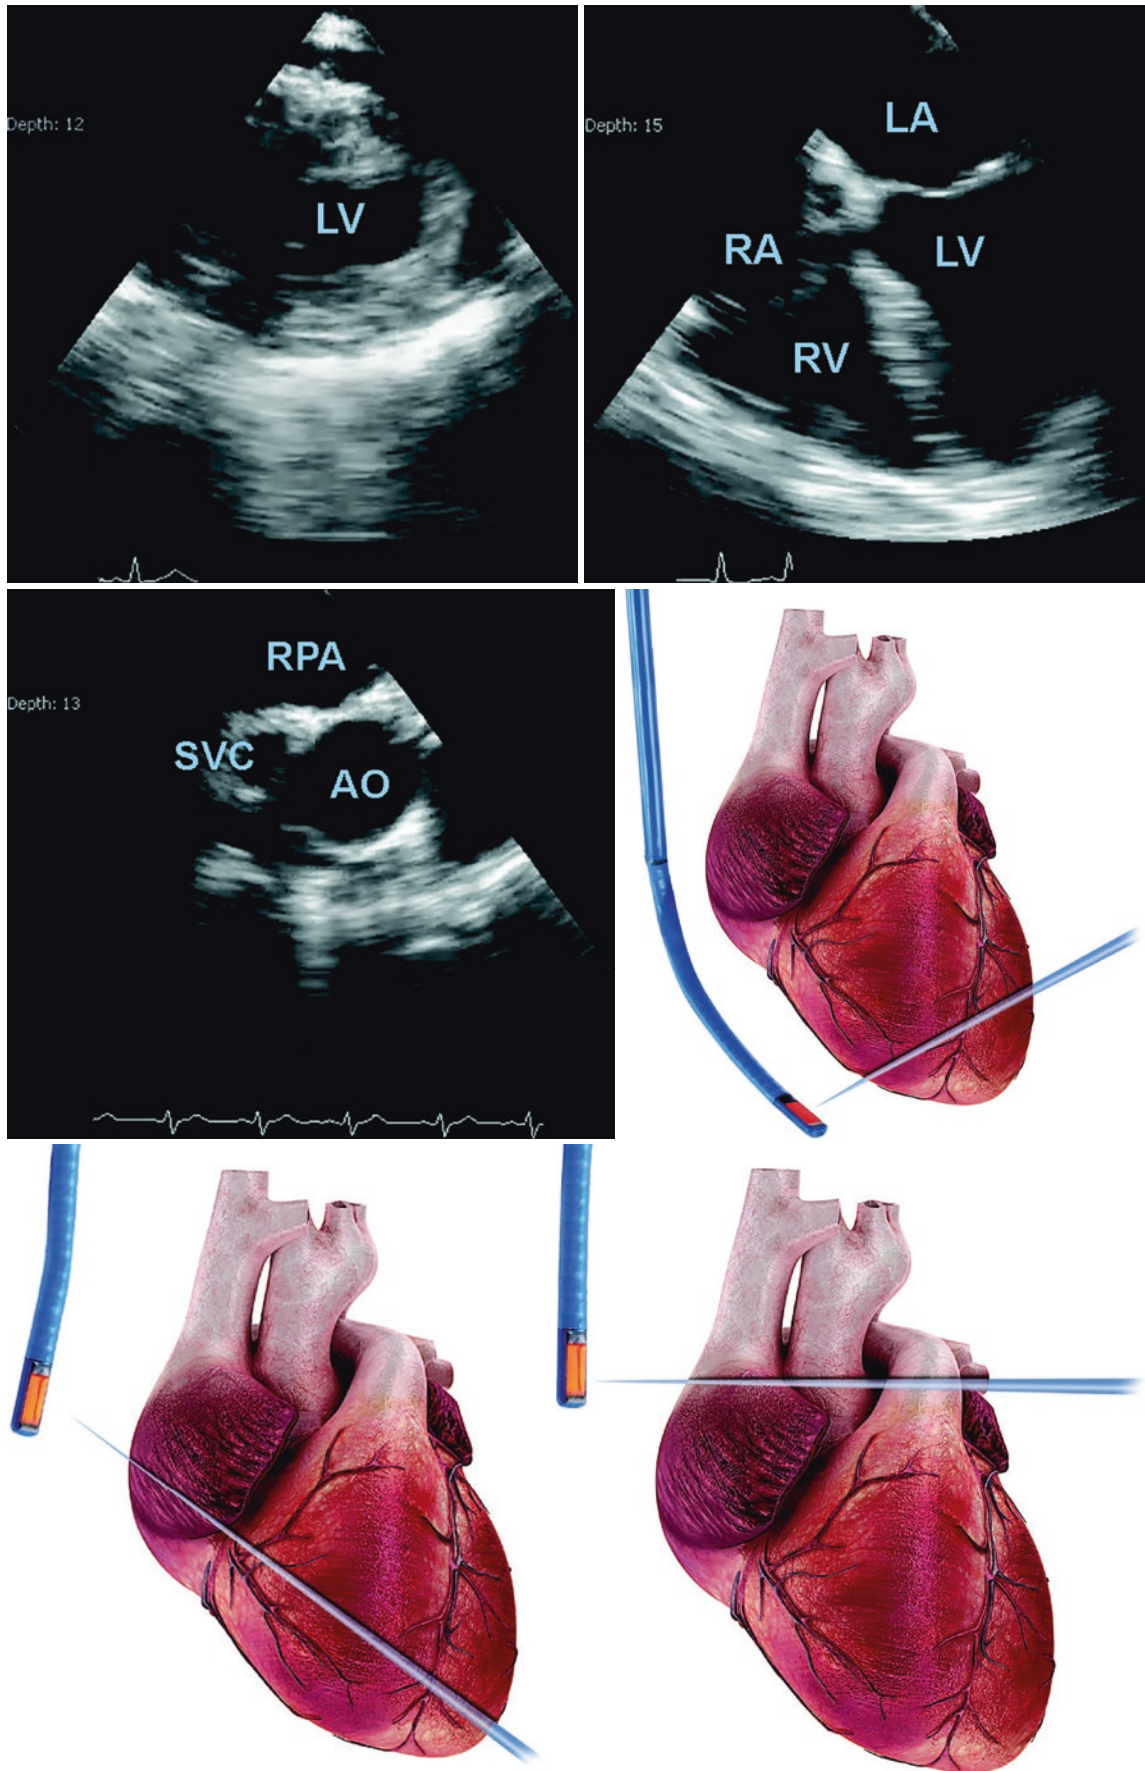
Hemodynamic transesophageal echocardiography probe position and corresponding image (With permission of ImaCor, Inc.)
